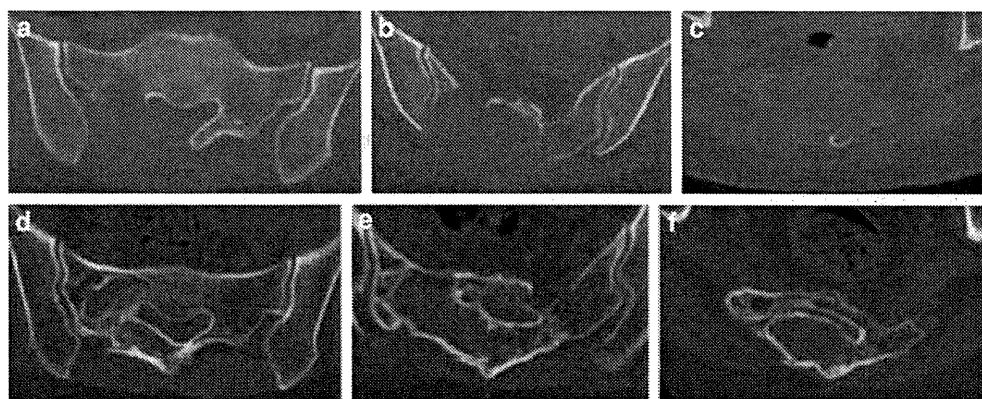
Computed tomography (CT) at a–c initial presentation and d–f 28 months after five embolizations. a, d Upper part; b, e middle part; c, f lower part. Ossification is seen at the periphery. Although the mass has not completely reossified, extraosseous mass has shrunk
